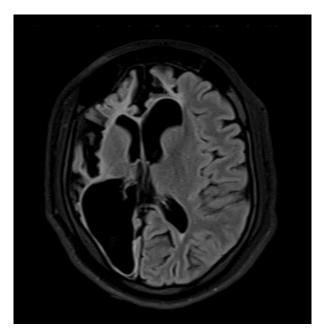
Axial FLAIR images in the same patient shows cortical atrophy with extensive white matter gliosis & hyperintensity and shrunken basal ganglia.
